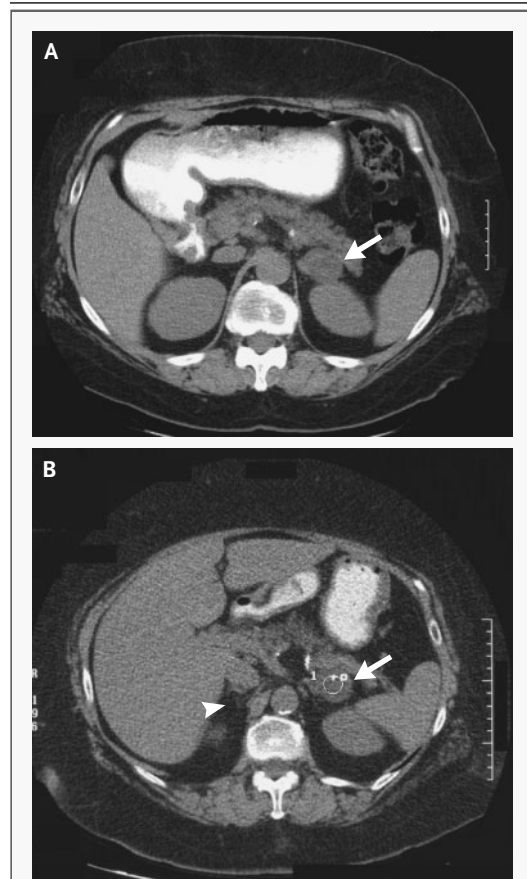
CT Scan of the Abdomen Obtained without the Administration of Intravenous Contrast Material.
